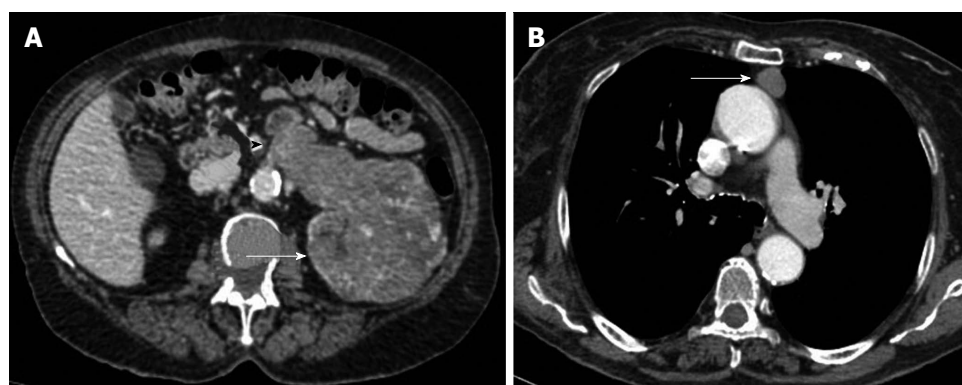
The 81-year-old woman with advanced-stage clear cell renal cell carcinoma of the left kidney. A: Transverse multiplanar reformation during the nephrographic phase shows large, inhomogeneously enhancing left renal malignancy (arrow), invading the ipsilateral renal vein (arrowhead); B: Contrast-enhanced computed tomography image of the thorax demonstrates enlarged mediastinal lymph nodes (arrow), with heterogeneous enhancement, suggestive for metastatic invasion.
